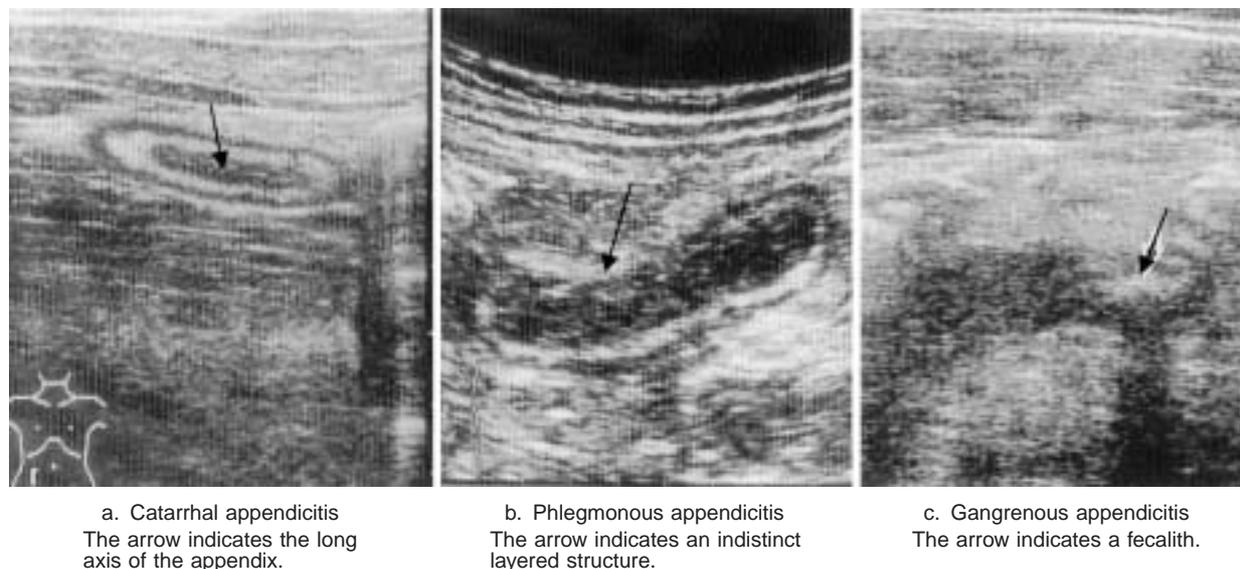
Ultrasonographic features of each type of appendicitis¹⁾
